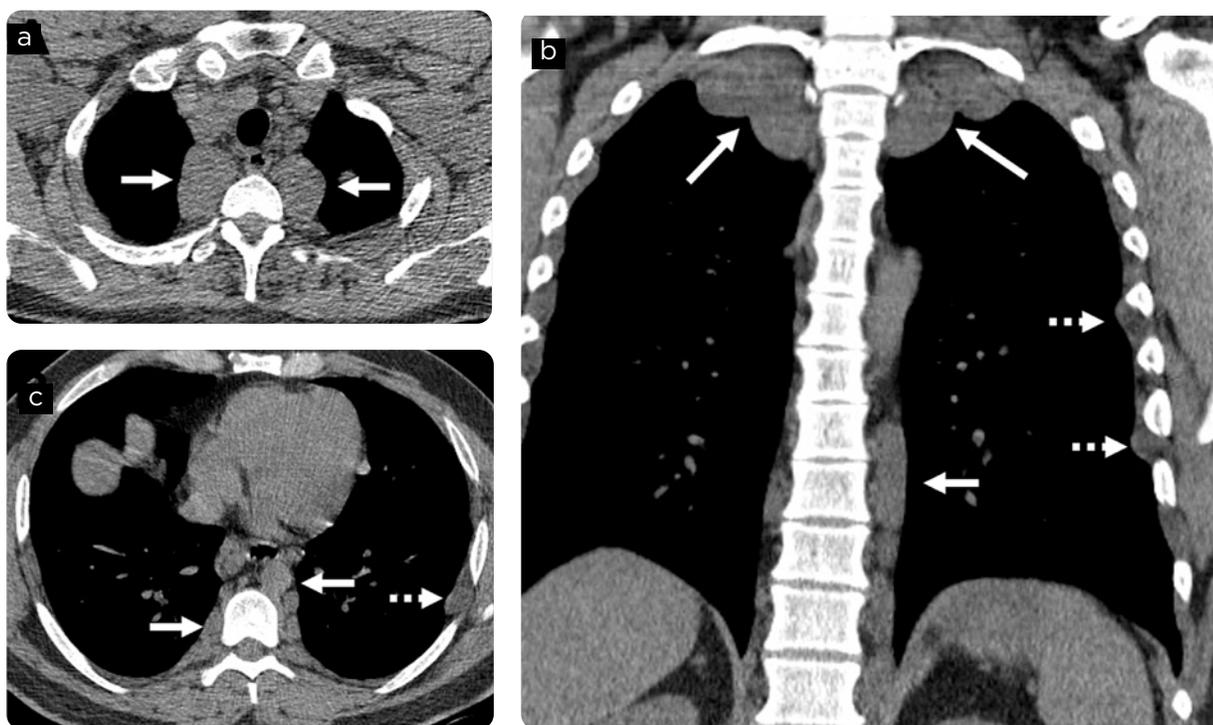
Patient with a history of neurofibromatosis. Simple multidetector CT of the thorax. a) Apical axial section in the upper lobes, b) caudal axial section in the upper lobes and c) coronal reconstruction. Nodular images with soft tissue density in the paravertebral mediastinal space (white arrows) and some in intercostal spaces (dotted arrow) corresponding to neurofibromas.
